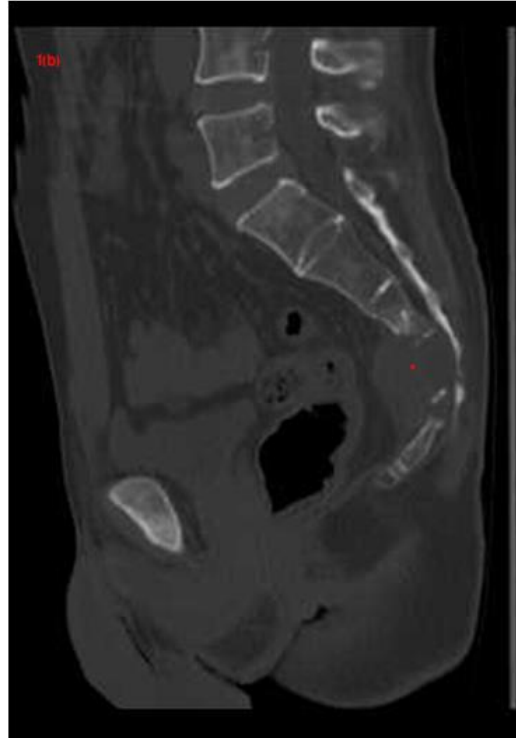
a-b: CT shows bone destruction and mass formation of sacral 4 vertebrae
